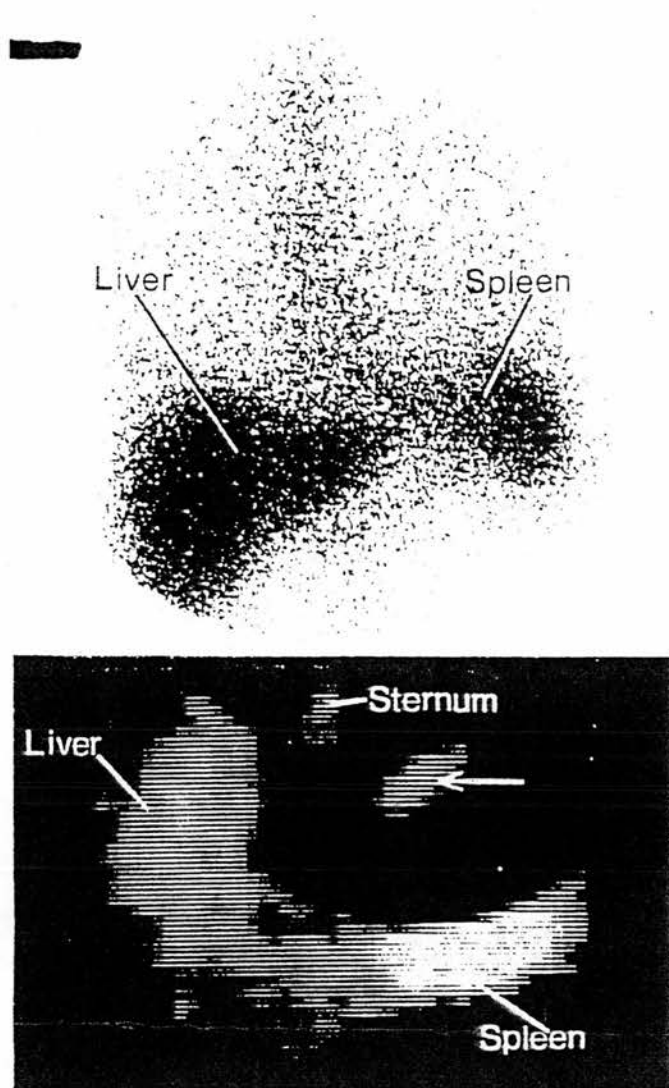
Anterior planar image with normal uptake in liver and spleen and no definite myocardial uptake (top). Single photon emission computed tomographic image (bottom) in the transverse plane showing uptake within liver and spleen and an area of focal myocardial uptake (arrowed).
